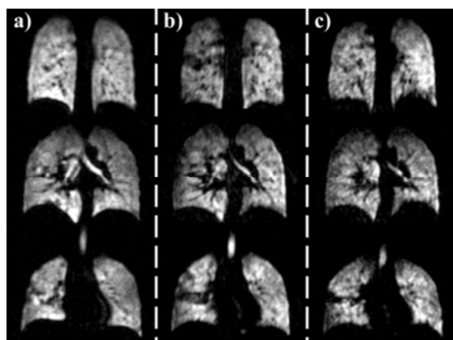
Comparative coronal MR image slices from a healthy smoker after inhalation of a) 200 mL HP  $^3\text{He}$ , b) 400 mL ENXe and c) 1 L NAXe, obtained at 1.5 T with an optimized 3D SSFP sequence.
